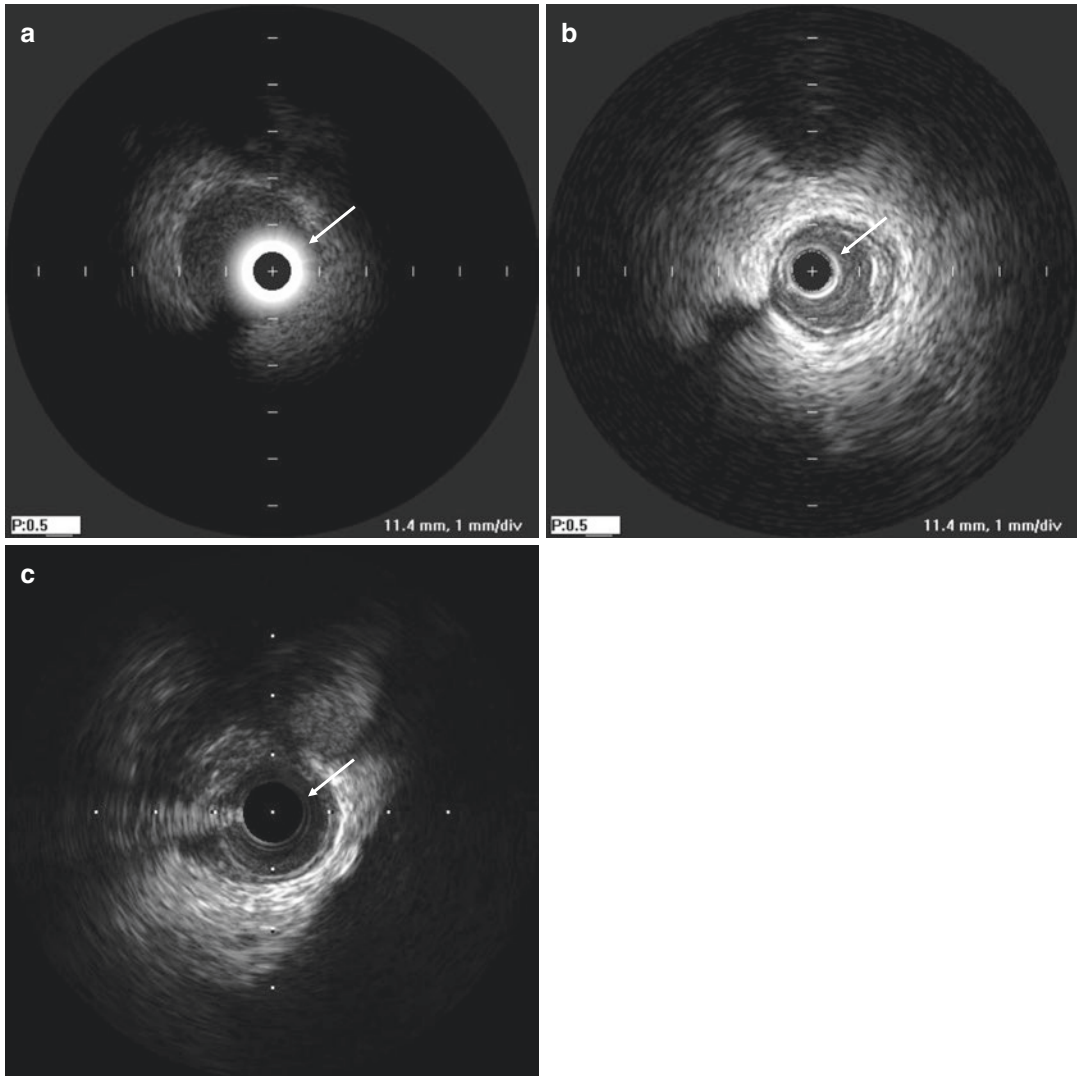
Ring-down or near-field artifacts. (a) An extremely displayed ring-down artifact can be noted due to ultrasound element defect (*arrow*). (b) Presented here
